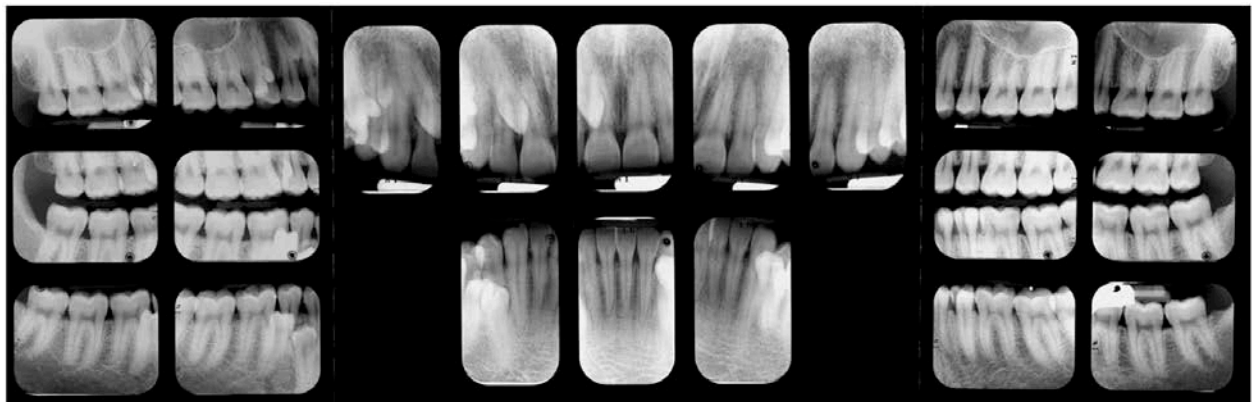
Full mouth radiographic survey of multiple supernumerary teeth. Note the size, shape, and location of the numerous supernumerary teeth.
